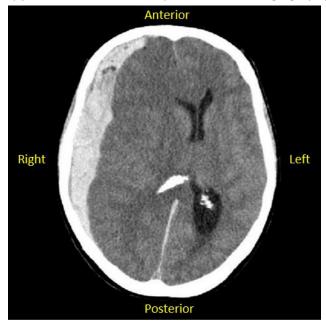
CT of the head. This CT shows a subdural hematoma on the patient's right (get used to orienting yourself). Also note the differentiation of gray and white matter in the brain.
